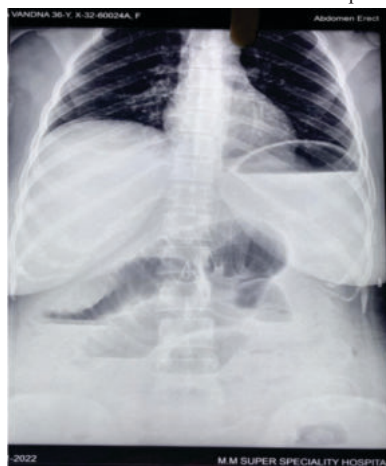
showing X-Ray Abdomen erect showing air under both domes of diaphragm and dilated loops of small bowel
